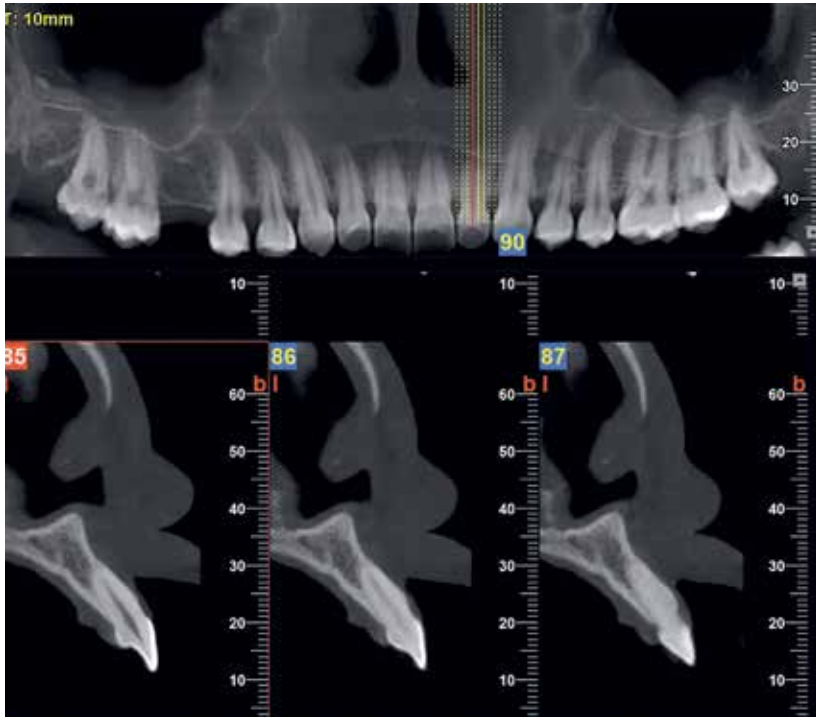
A CBCT panoramic reconstruction (*top*) and a series of cross-sectional images (*bottom*) of the anterior maxilla for the assessment of the integrity of the cortical plates and incisor root position inside the alveolar ridge.
